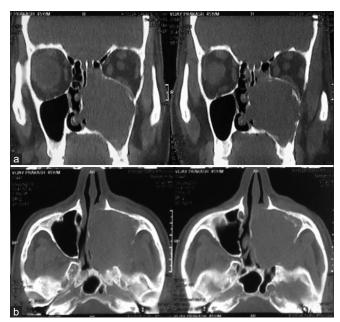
Computed tomography scan showing (a) coronal section revealing soft-tissue density measuring 5 cm × 4 cm × 3 cm involving the left maxillary sinus, few anterior and posterior ethmoidal air cells, pterygopalatine fossa, and infratemporal fossa with the bony erosion of the superior wall of the maxillary sinus and orbital floor. (b) Axial section mass pushing the nasal septum to the right side and extending into the pterygopalatine fossa and erosion of the medial, lateral, and posterior walls of the maxillary sinus
